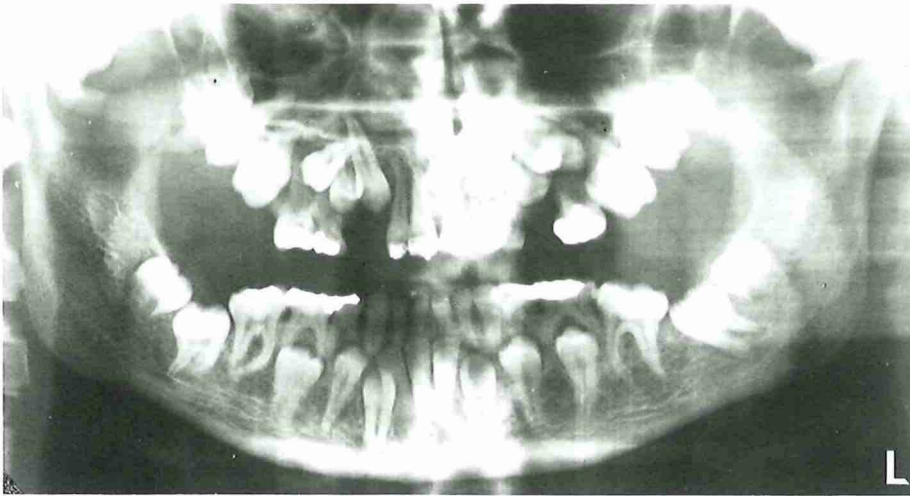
Orthopantomogram of a 16-year-old man with cleidocranial dysostosis. Multiple unerupted teeth are present in the mandible and maxilla.
